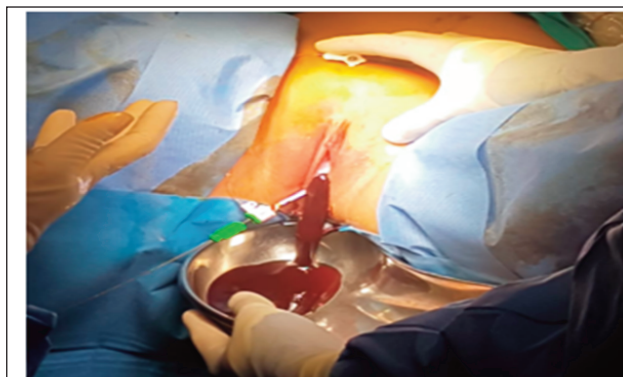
Ultrasound guided needle puncture and drainage of blood.
